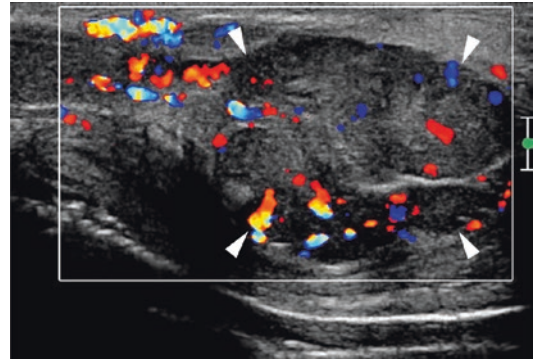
Metastatic involvement from prostate cancer. A 79-year-old patient with already known prostate cancer presented with painful induration of the penis. Colour Doppler ultrasonography shows tumour tissue growing within the corpora cavernosa, most prominent in the crura (*arrowheads*), consistent with metastatic deposits of the prostatic cancer
